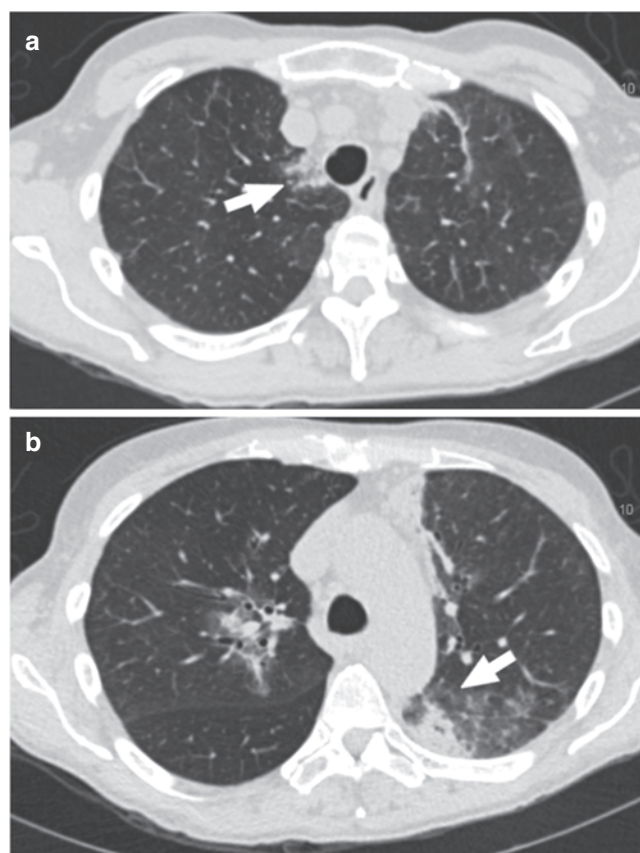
Conventional CT image shows bilateral areas of peripheral reticulation, clustered nodular opacities, and ground-glass attenuation in the right upper lobe (a) and left lower lobe (b). Central airways are patent without suspicious filling obstruction. No significant pleural effusion or pneumothorax is appreciated
